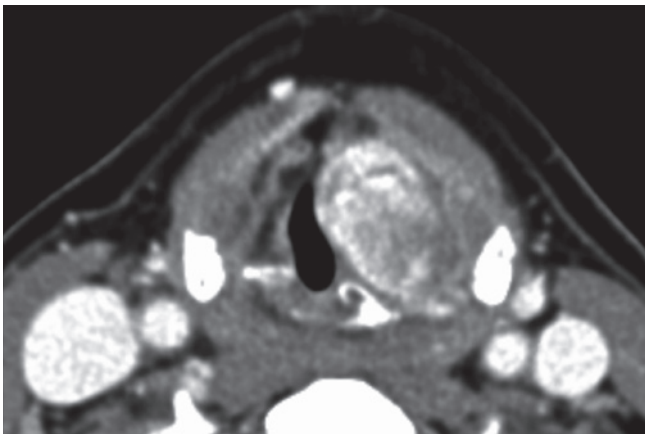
CT-scan with contrast axial view showing low enhancement in both arterial and venous phases. The mass widens the thyroarytenoid space without cartilage infiltration.
